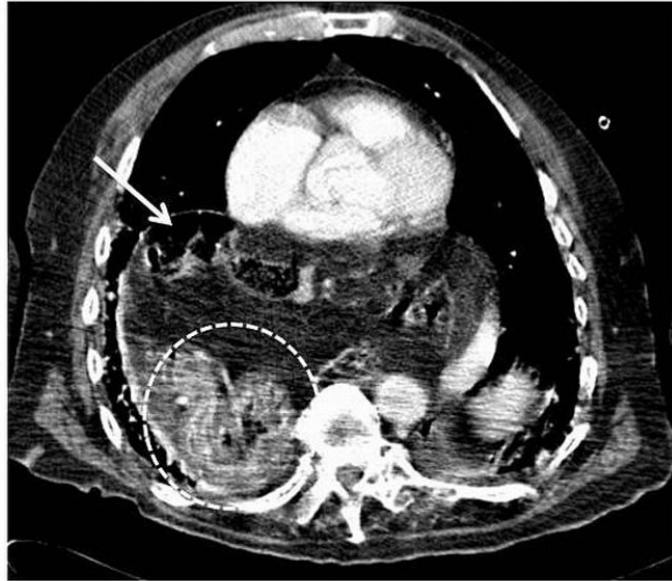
Organoaxial volvulus: this axial plane of abdominal CT (soft tissue window), after contrast, shows a huge hiatal hernia (white circle indicating the stomach) associated to herniation of transverse colon (arrow). There are not signs of ischemia.
